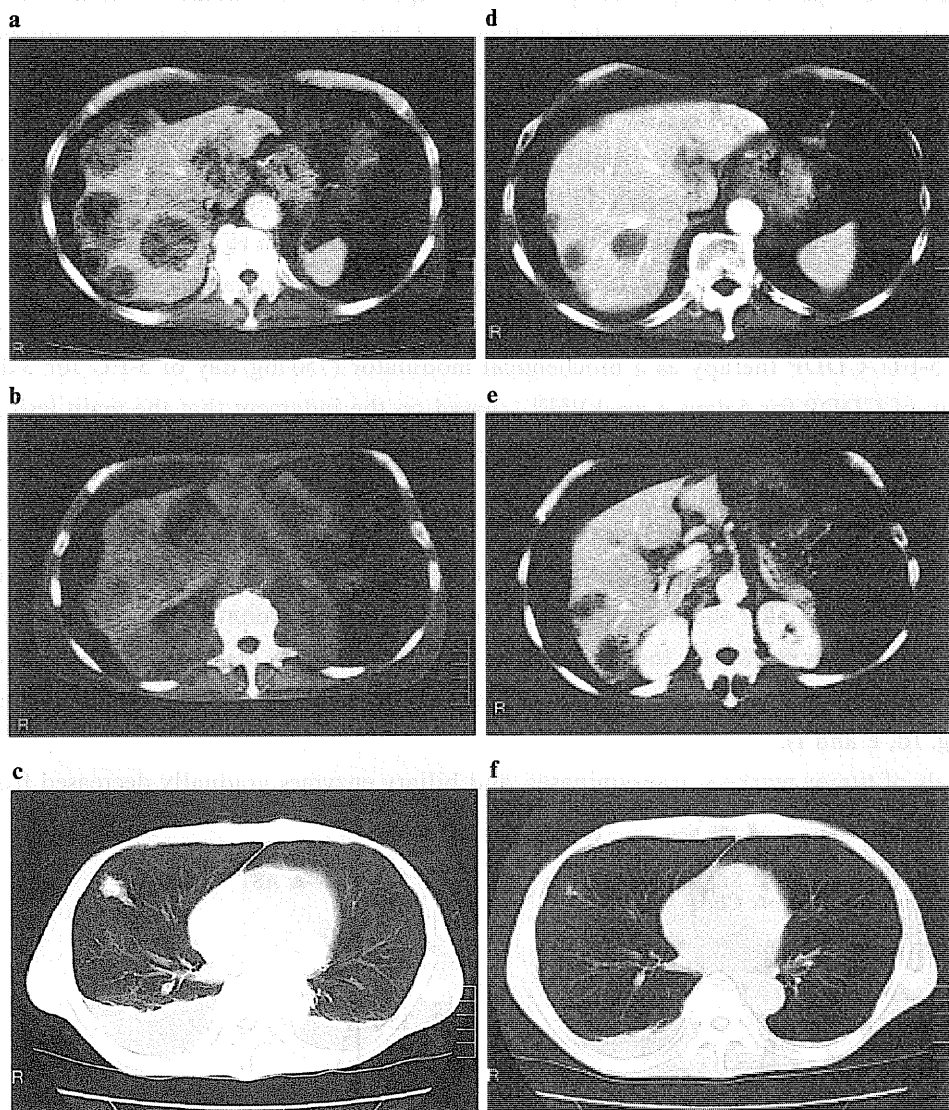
CT findings on admission (a, b and c) and 3 months after treatment (d, e and f).
